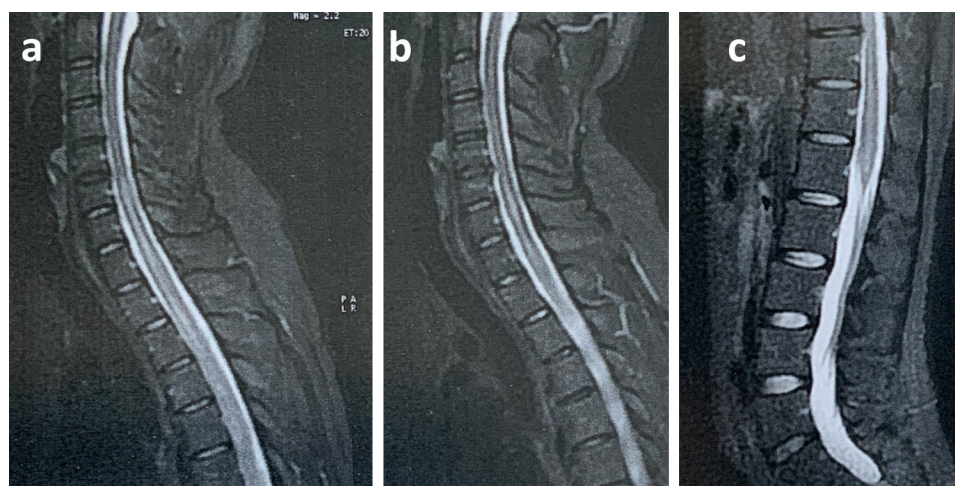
Spinal MRI on T2WI demonstrating a longitudinal hypersignal of the spinal cord from the cervical segment (C5–C6) (a and b) to the conus medullaris (c).
